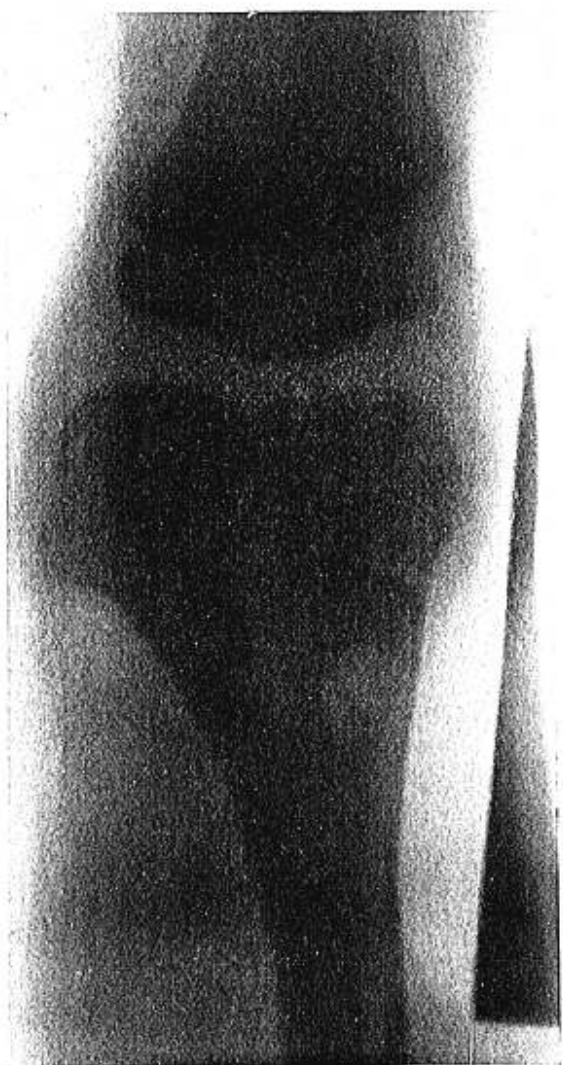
Radiograph taken Jan. 8, 1964, eighteen months after operation, showing normal position of epiphysis. Anteroposterior view.
